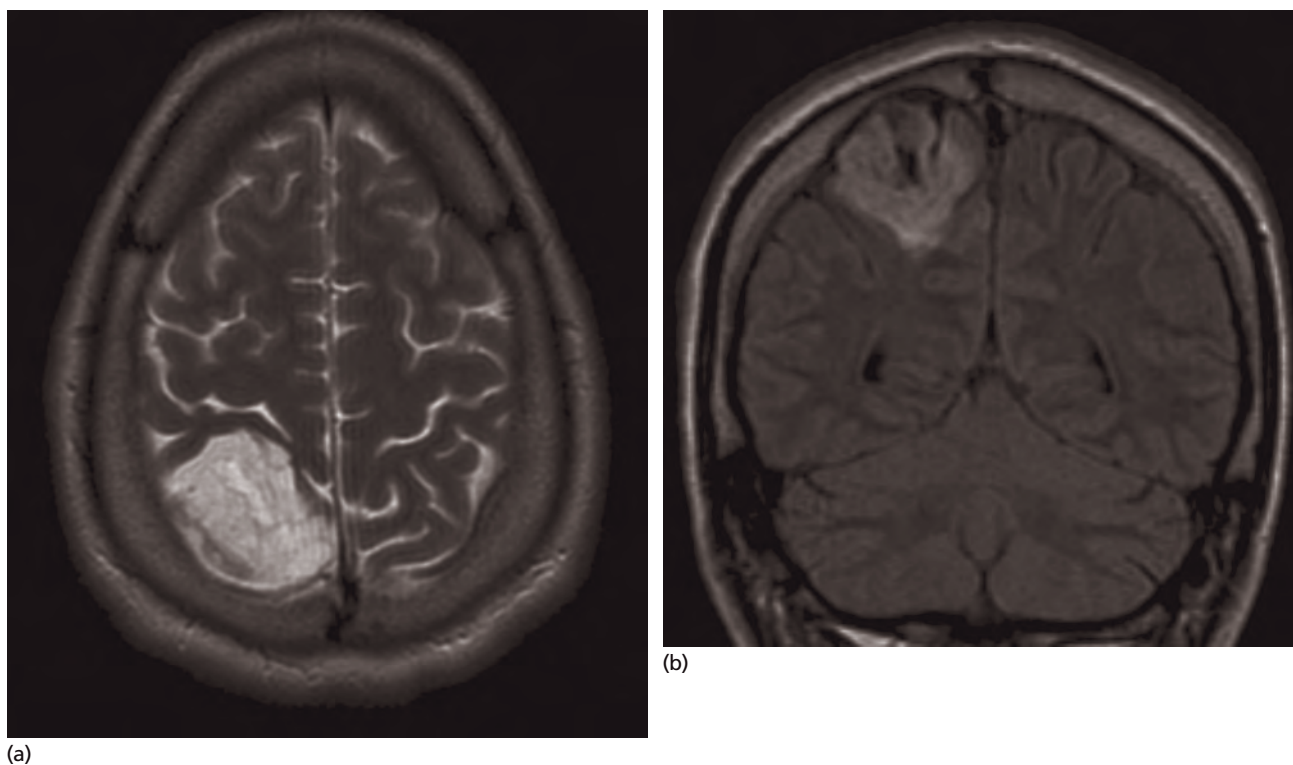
(a) T2 image of right parietal hyperintense mass that proved to be a dysembryoblastic neuroepithelial tumour (DNET). (b) Coronal FLAIR image shows cystic components within DNET with scalloping of inner table of the skull, indicating slow growth of this neoplasm.
